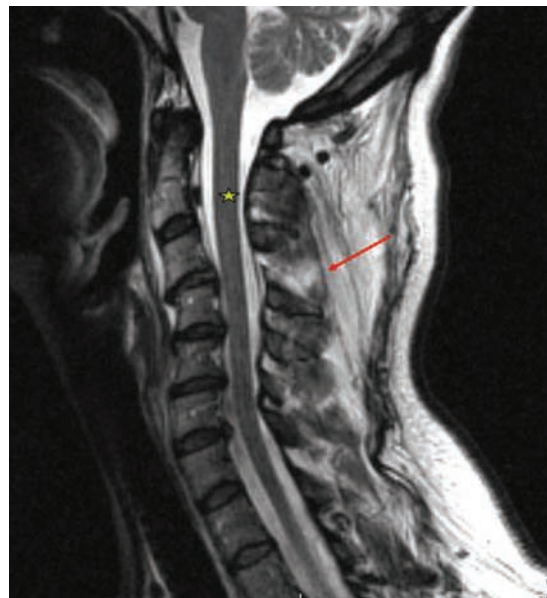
Sagittal T2 weighted magnetic resonance image. The affected region (arrow) shows high signal intensity associated with discontinuity of the ligamentum flavum, consistent with disruption to the ligamentum flavum and interspinous ligament. The appearance of the spinal cord (asterisk) was normal
